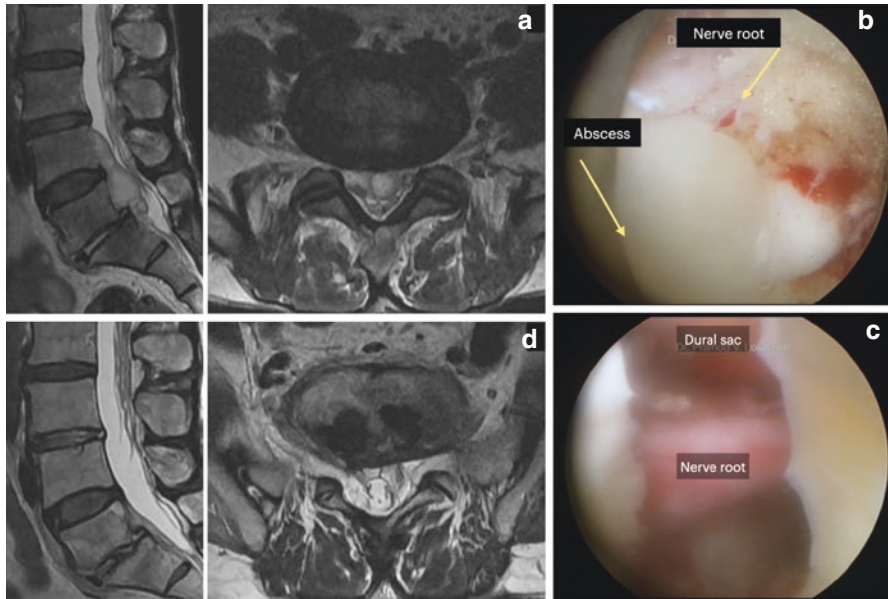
(a) Preoperative MRI pictures showing large ventral epidural abscess from L5S1 disc level to upper margin of L4 body. L5S1 disc space was not significantly involved. (b) Endoscopic picture showing liquid abscess seen after the nerve root was retracted. Abscess was drained and irrigated with fluid. (c) Endoscopic picture showing dural sac and nerve root through the slit in the ligamentum flavum after complete removal of abscess. (d) Postoperative MRI after 3 months showing complete resolution of abscess and relatively undamaged L5S1 disc space
